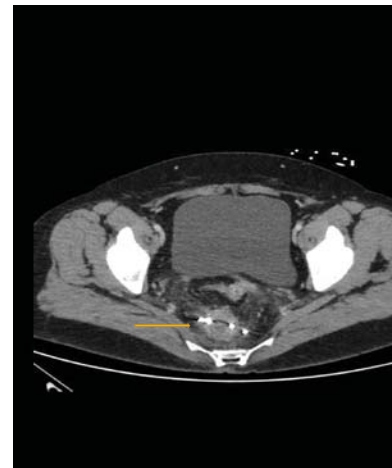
CT scan showing F.B. in the rectum (yellow arrow).
